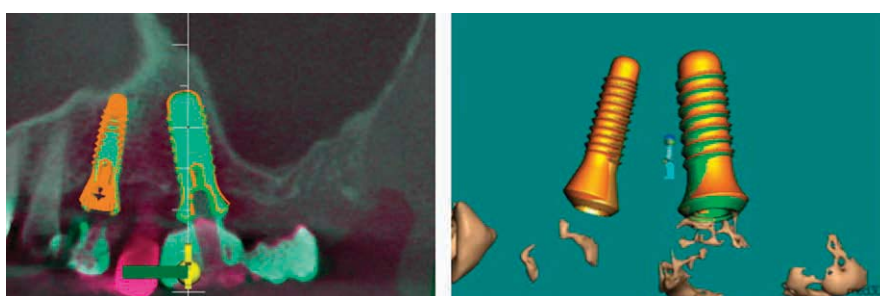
The matching procedure on fused 3D images of pre-surgical planning and postsurgical cone beam computed tomography scan generated by the med3D software. Planned implants are represented by the orange colour and actual implants are represented by various colours.
